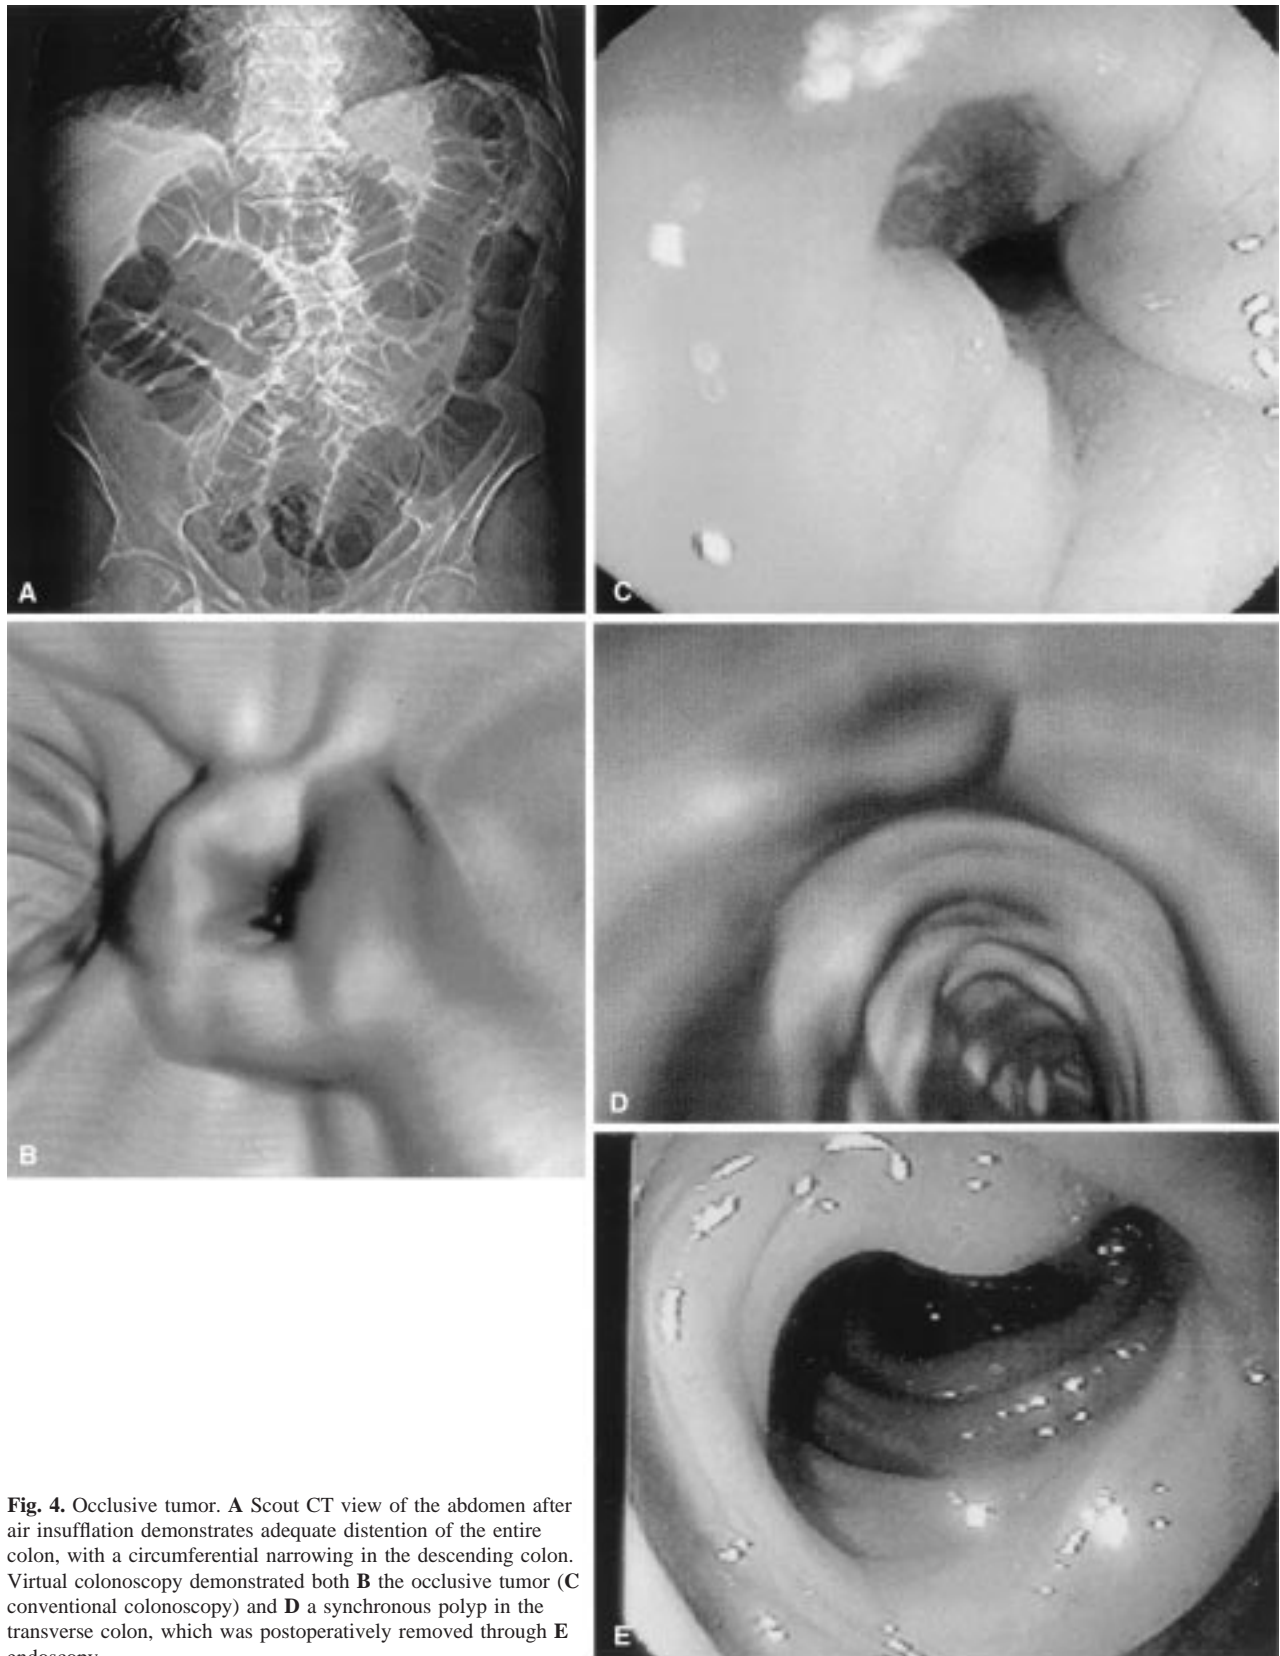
Occlusive tumor. A Scout CT view of the abdomen after air insufflation demonstrates adequate distention of the entire colon, with a circumferential narrowing in the descending colon. Virtual colonoscopy demonstrated both B the occlusive tumor (C conventional colonoscopy) and D a synchronous polyp in the transverse colon, which was postoperatively removed through E endoscopy.
